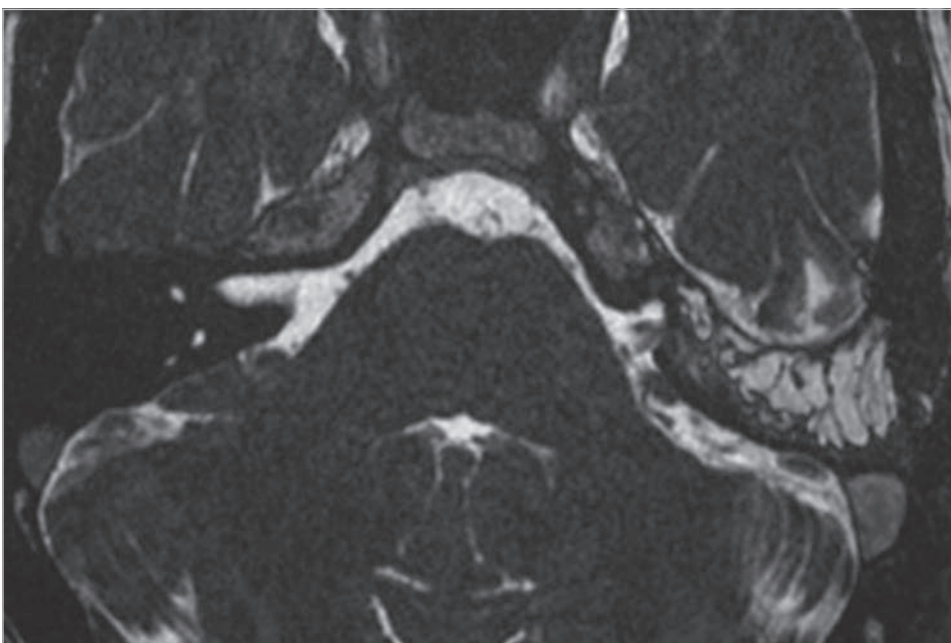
The postoperative MRI shows extensive removal of bone from the temporal bone.
